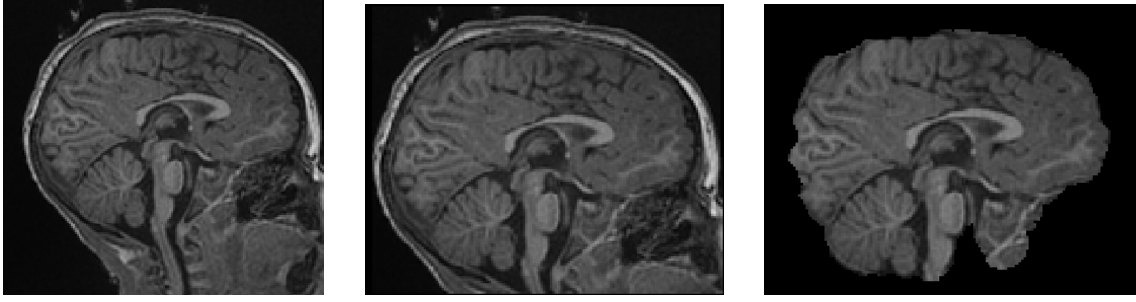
Brain extraction using FSL on subject 2. On the left, the initial anatomical MRI, in the middle, the anatomical MRI with cropped neck and on the right, the extracted brain.
